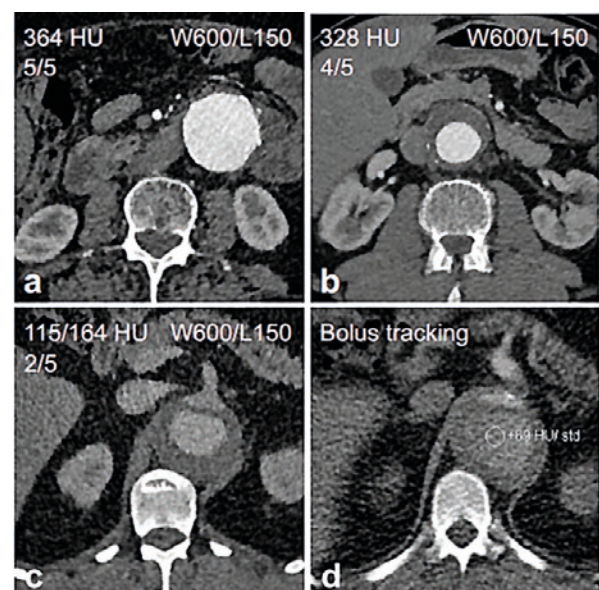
The LD protocol CTA demonstrates sufficient diagnostic quality except in image d), where the tracking of aortic dissection is impeded. (Source: <https://pubmed.ncbi.nlm.nih.gov/35328228/>)
